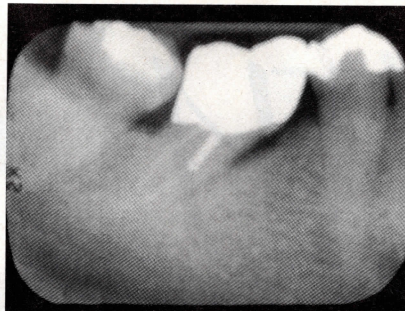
Postrestorative radiograph of situation depicted in Figure 2A. Although restored, the reparative potential of uprighting has not been exploited. The angular crest remains, and the presence of endodontic treatment suggests a pulpal exposure.
